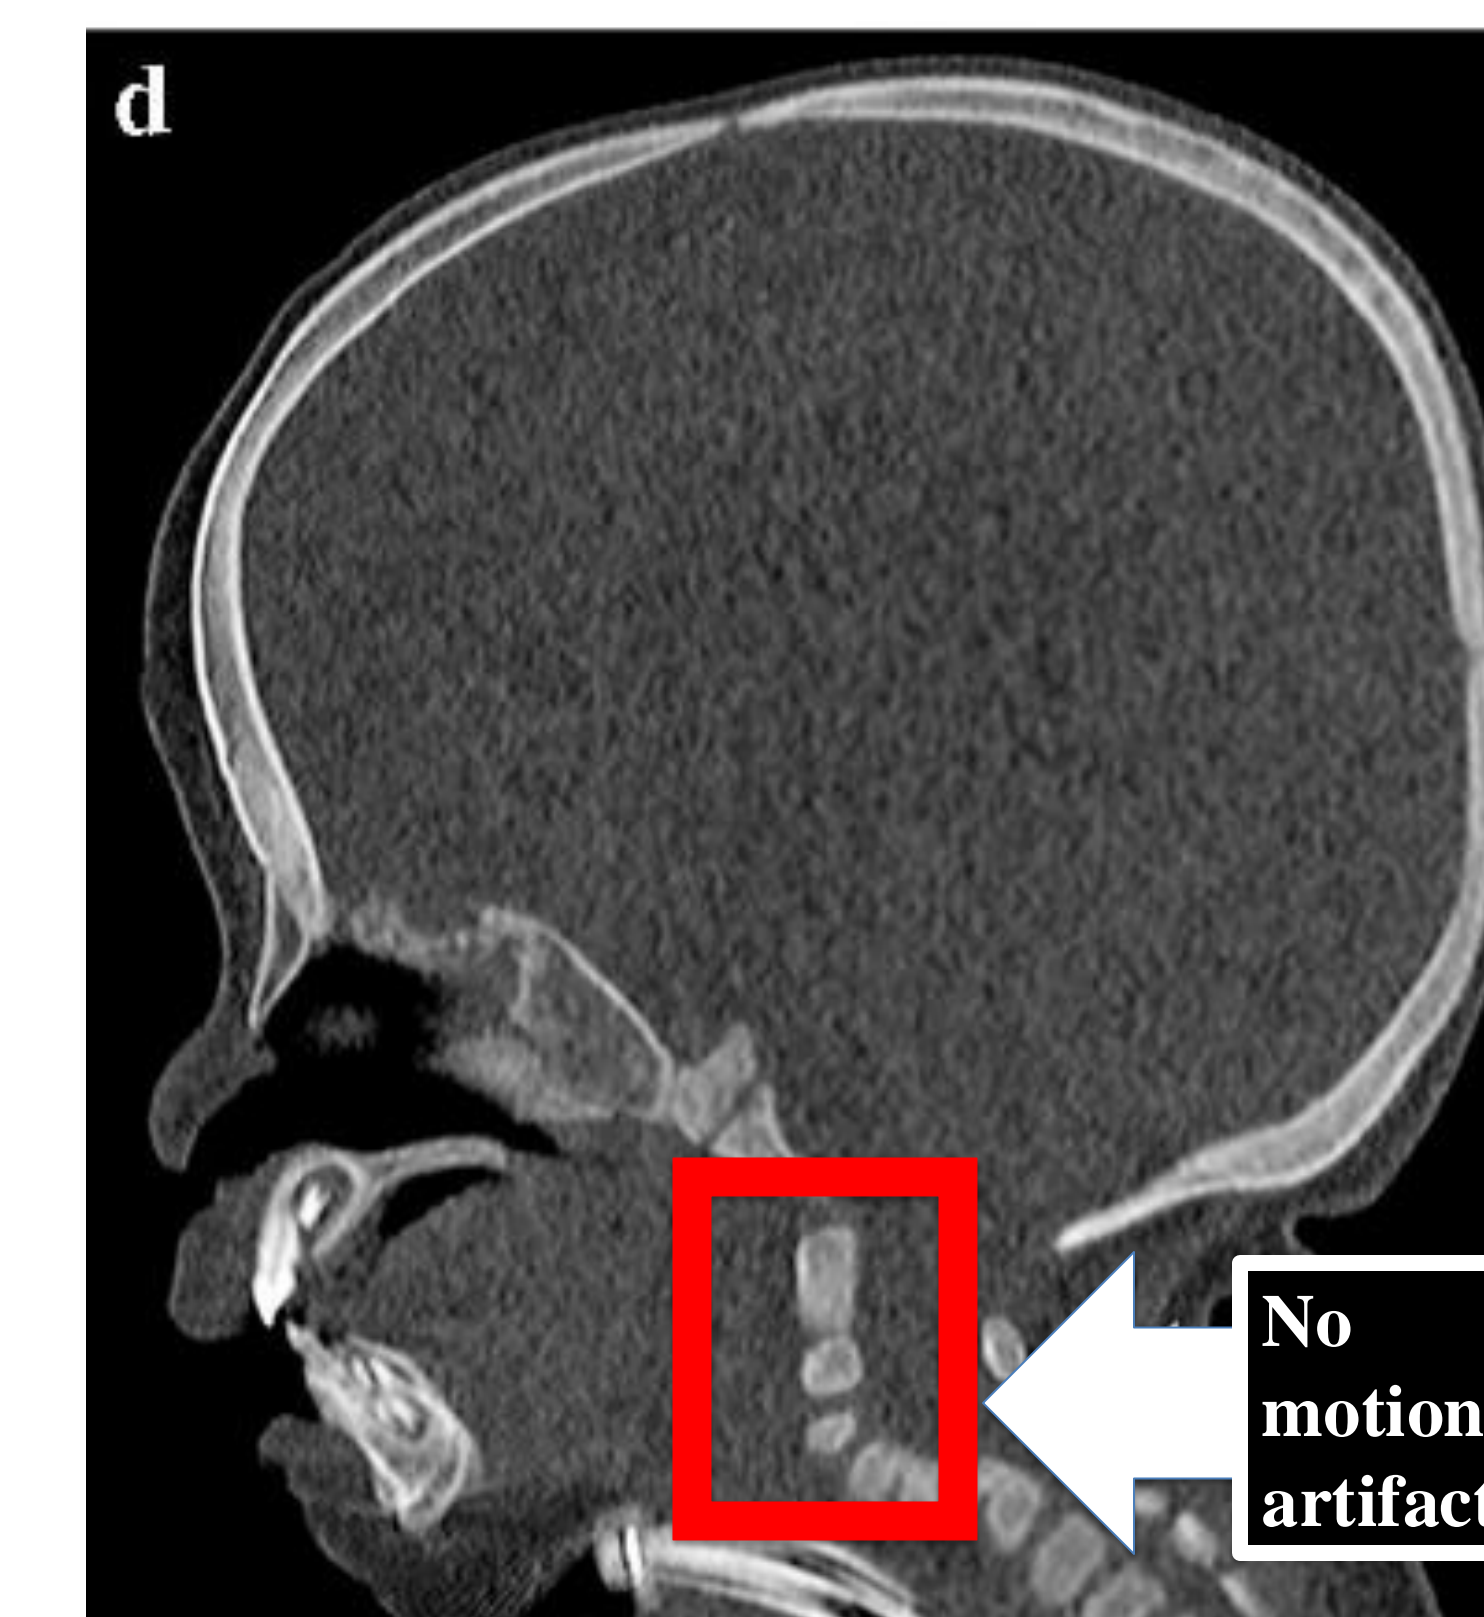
This sagittal CT can be compared to Image 3 above. The cervical spine is demonstrated without motion artifact, allowing for a more accurate diagnosis (Barreto et al., 2021, p. 94).
